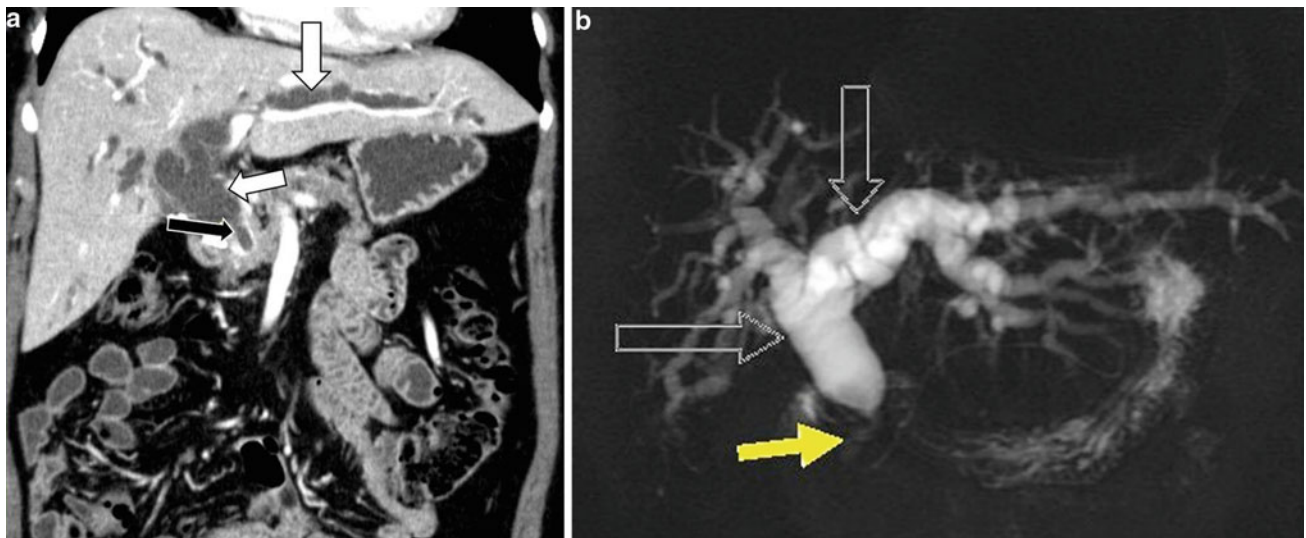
Carcinoma of the common bile duct. a Coronal view reconstruction of contrast-enhanced CT reveals enhancement of the thickened wall of a 2-cm stricture in the distal common bile duct (black arrow) and marked intra- and extrahepatic bile duct dilatation
